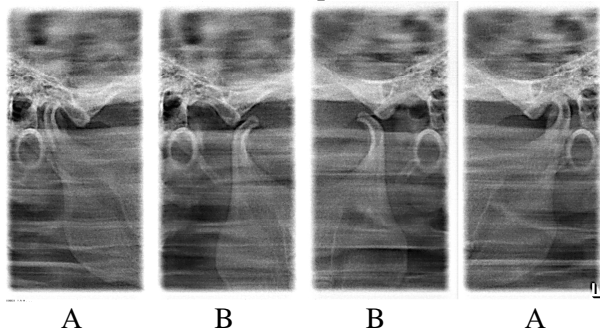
Targeted X-rays of TMJ with closed (A) and open (B) mouth of the patient with clinical phenomena of hypermobility of the articular heads.
